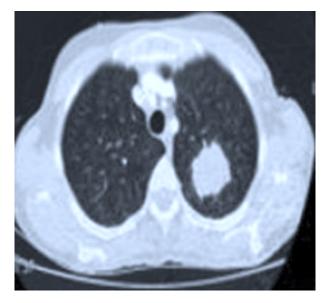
CT Scan of chest.
